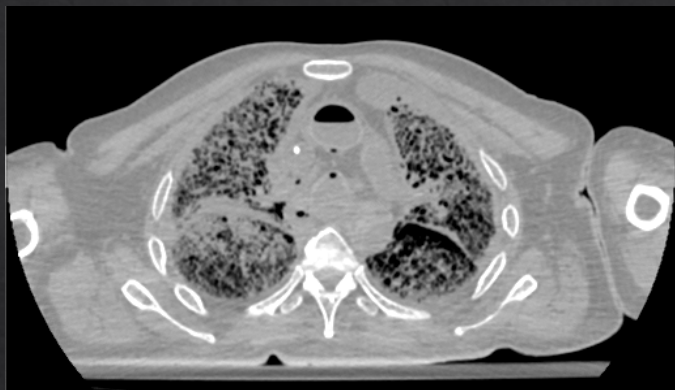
A CT image taken at 17 mGy
